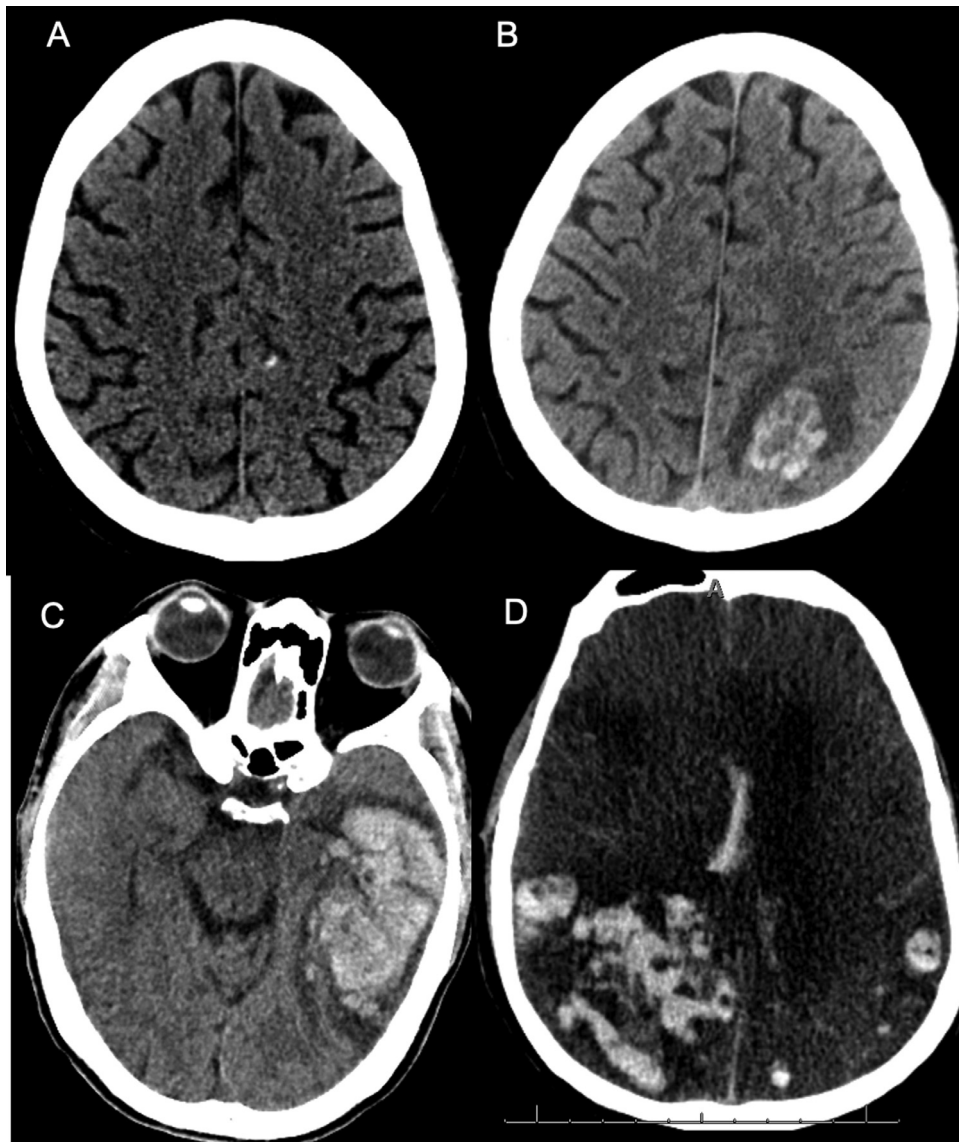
CT images of four different patients demonstrating petechial hemorrhage in a small cortical infarct (A), infarct with small hemorrhage (<5 cm) (B), single site of large parenchymal hemorrhage with local mass effect (C), and multiple sites of parenchymal hemorrhages with mass effect and herniation (D).
